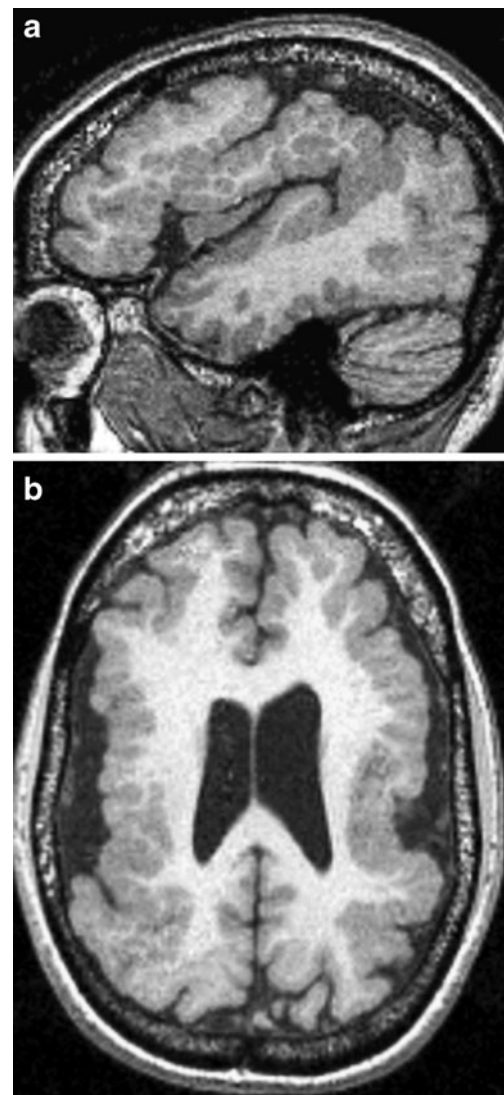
Grade 1 perisylvian PMG. Parasagittal (a) and axial (b) T1-weighted images show coarse polymicrogyria extending from the frontal pole to the occipital pole
